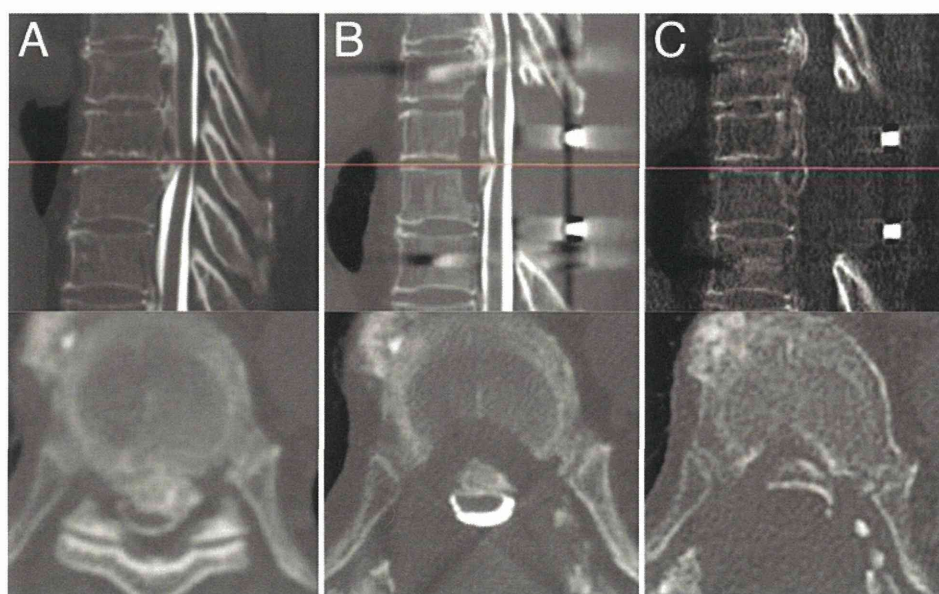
Case 4. OPLL at T8-9 treated by means of the plaque-floating technique. A and B: Preoperative (A) and 1-month postoperative (B) CT myelograms. C: Postoperative plain CT image obtained 6 months after surgery. Figure is available in color online only.
